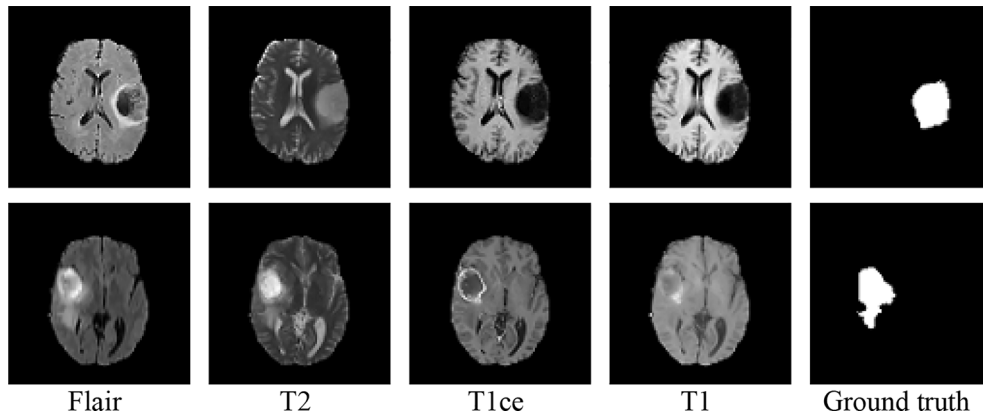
Examples of a brain tumor in two patients A (top row) and B (bottom row) with 4 MRI modalities (Flair, T2, T1ce, T1) and physician' delineation of tumor region.
